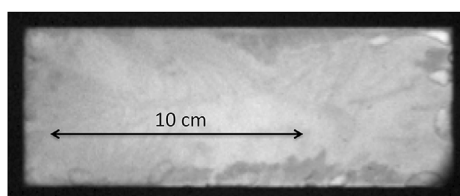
Macroscopic inhomogeneities in the T_1 weighted MRI image of a $\frac{1}{2}$ L cryogenic PVA gel scanned at 1.5 T using a head coil and an inversion–recovery sequence optimized for brain scans.
